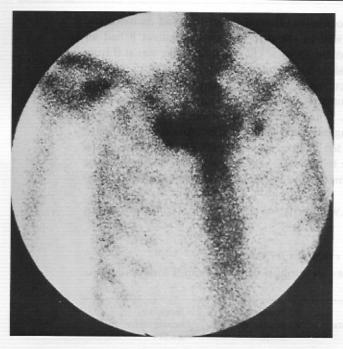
Skeletal scintigraphy of the thorax from the front in a 60-year-old woman with PPP for ten years. There is an increased radioactivity on the right side of the manubrium sterni, anterior part of the first rib and the SCC junction. Clinically the patient was free from symptoms.
